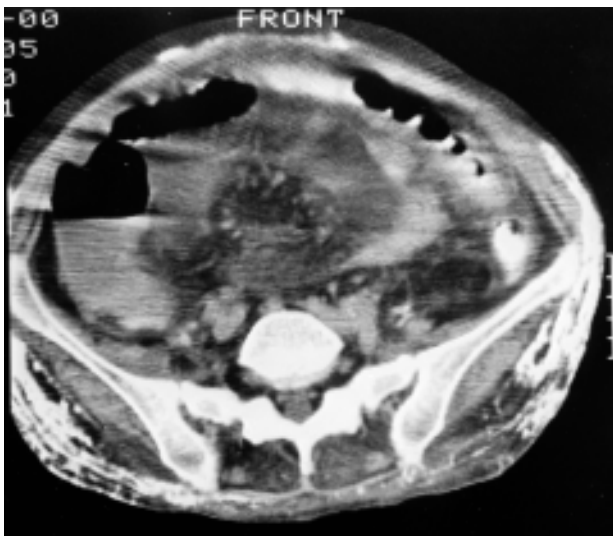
Abdominal CT scan showing sigmoid colon diverticulae and free intraperitoneal fluid.
